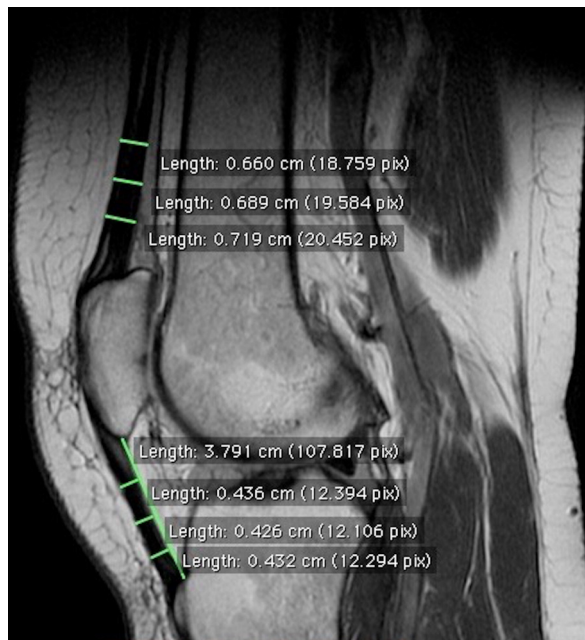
Sagittal MRI measurements. Patellar tendon thickness was measured three times. Similarly, the quadriceps tendon thickness was measured at three levels. Patellar tendon length was measured from the posterior insertion of the tendon to the tibia to the posterior insertion of the tendon to the patella.
